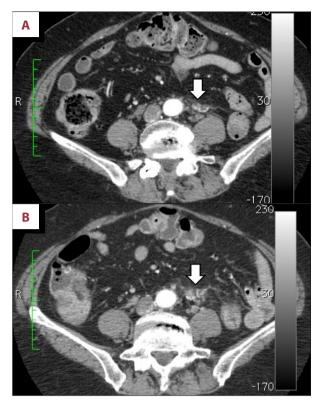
(A) Axial view computed tomography (CT) scan in the early phase obtained one and a half years after radical colectomy. Indistinct interstitial changes with enhanced vessels are observed adjacent to the abdominal aorta (white arrow). (B) CT scan obtained 3 years after the operation. The lesion changed in shape, but was not confirmed to be a tumor (white arrow).
